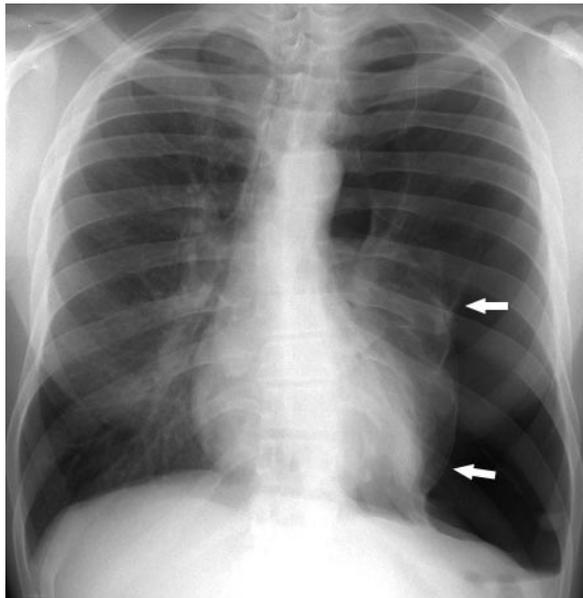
Spontaneous left-sided pneumothorax in a 33-year-old man who had been smoking crack cocaine. The patient presented with chest pain and had no history of trauma. Chest radiograph demonstrates hyperlucency of the left hemithorax and clearly depicts the visceral pleural line (arrows).
